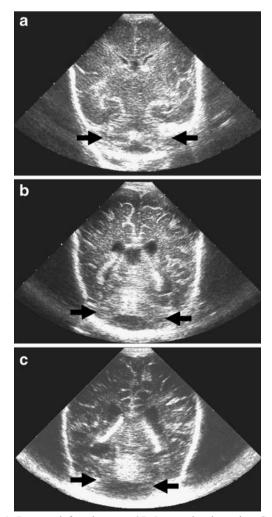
Preterm infant born at 27+5 gestational weeks. Coronar ultrasound scan shows a normal cerebellum at day 6 (a), cerebellar reduction at day 65 (b), and severe cerebellar reduction with nearly empty posterior fossa at day 99 of life (c)
